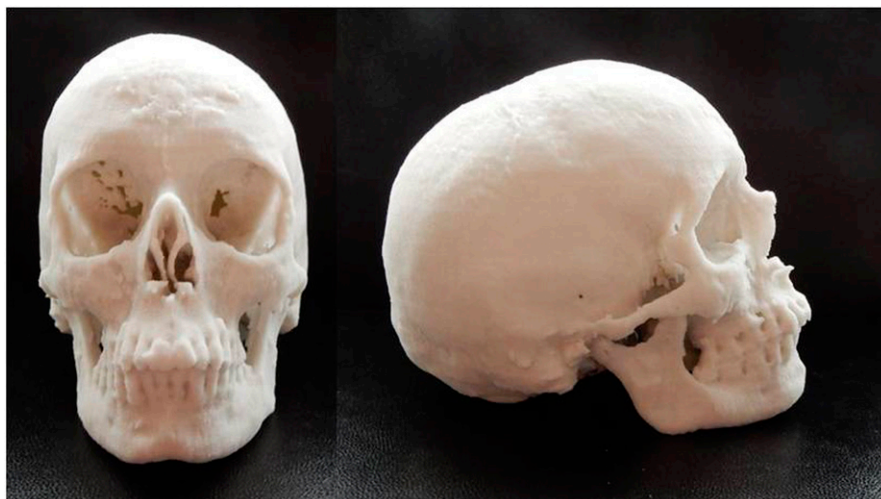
A three-dimensional printed model of the craniofacial skeleton of an adult volunteer from "Black Bone" MRI data.
